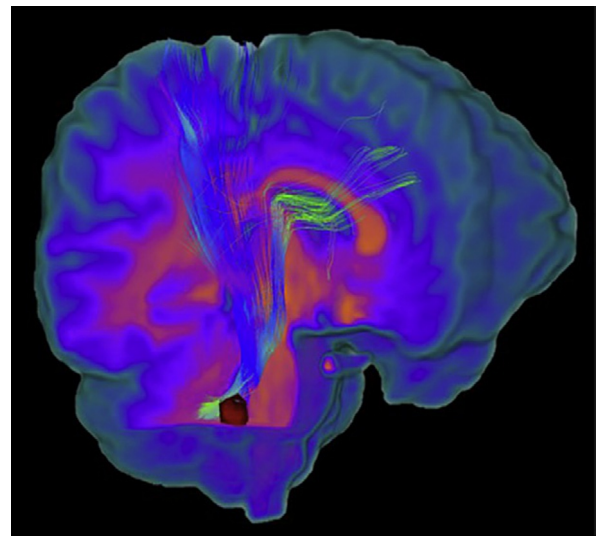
Diffusion tensor imaging-based tractography in a patient with mild traumatic brain injury. Overlying the three-dimensional rendered imaging of the patient’s T1-weighted image, fiber tracts generated from the patient’s diffusion imaging emanate from a region of interest in the right middle cerebellar peduncle (red).
